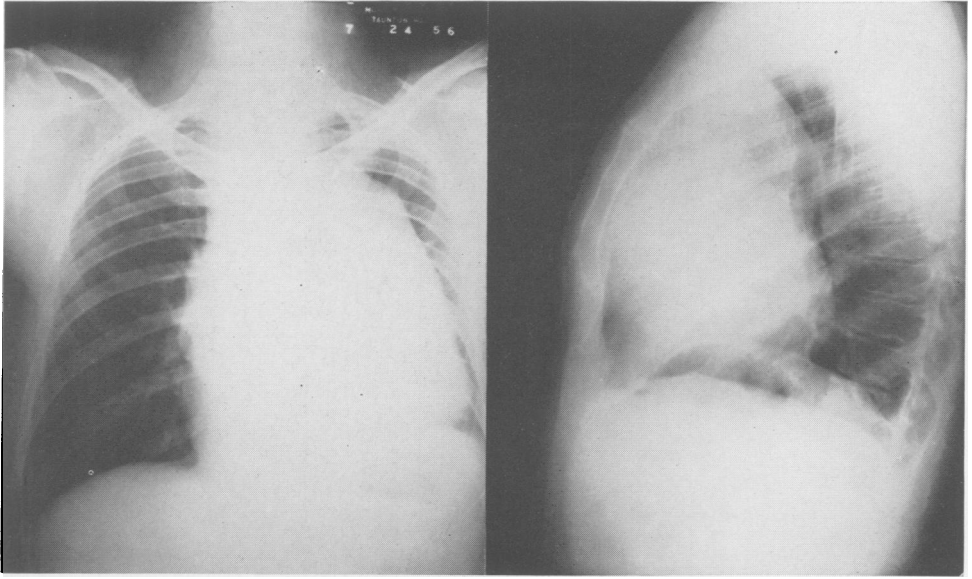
Chest roentgenograms of a patient with glandular carcinoma of the thymus and Cushing's syndrome.
